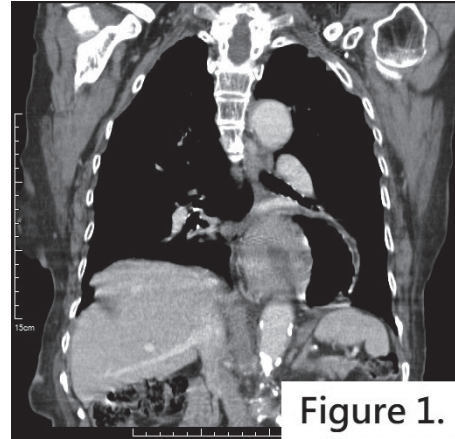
Herniation of bowel loops in the thoracic cavity was revealed on chest computed tomography.
